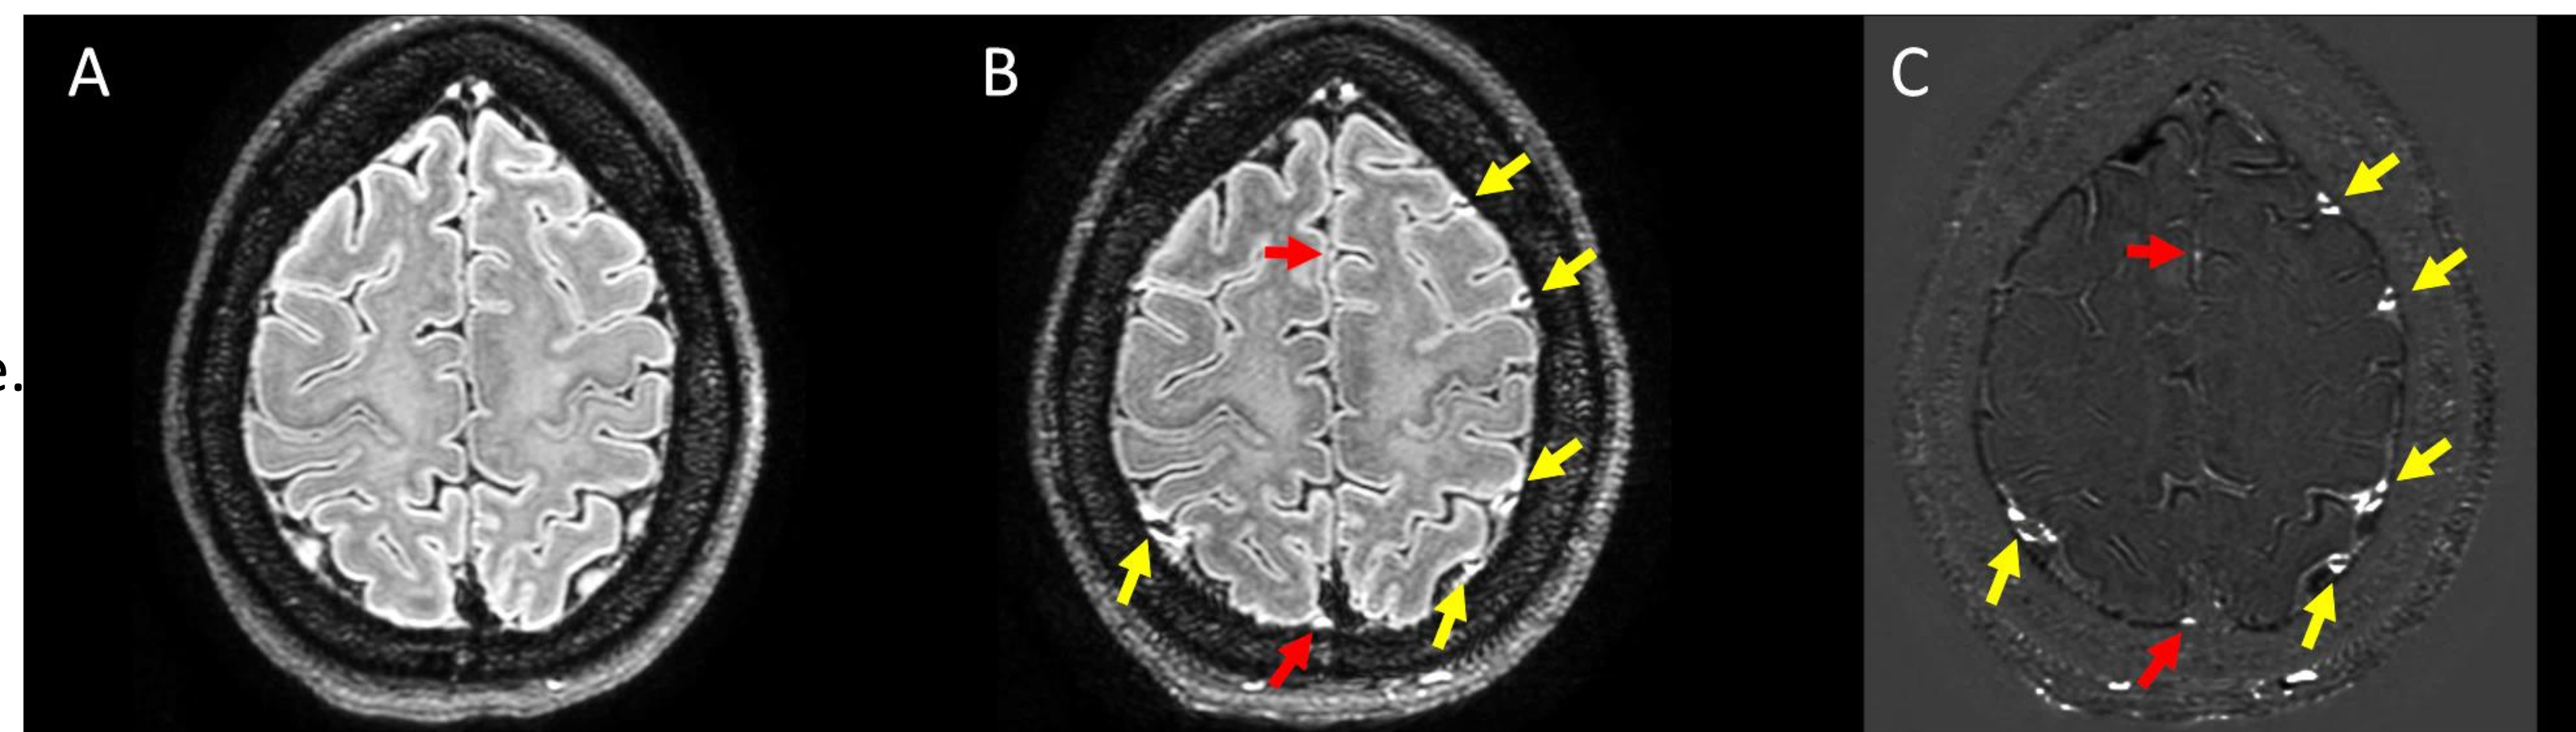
Process for identification of PDE. Shown are an examples of perivascular/dural enhancement (PDE). To identify such foci, co-registered pre-Gd FLAIR (A), Gd+ FLAIR (B), and subtraction (Gd+ minus Gd- (C)) were reviewed. Regions of hyperintensity on subtraction maps were confirmed on anatomic images. Hyperintensities surrounding large dural/cortical veins (as visualized by a central flow void) were labelled as perivascular (yellow arrows). Nodule-like hyperintensities in dura or adjacent to dural sinuses (red arrows) were labelled as dural enhancement. Together, these two foci were categorized as PDE.
